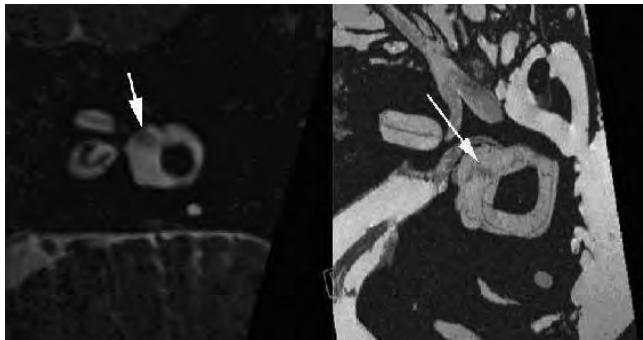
Left, 3T MR image using 3D SPACE technique demonstrates low signal utricular macula of the membranous
